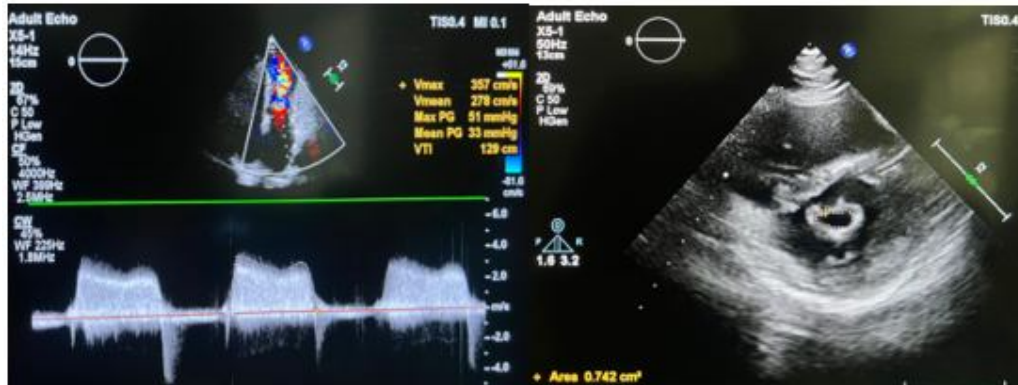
(A) Colour Doppler across MV showing turbulent jet due to MS and CW showing P/M TMG of 51/33 mm Hg suggestive of severe MS. (B) PSAX view showing Fish mouth appearance of MV in open state in diastole with MV area of 0.74 cm² by Planimetry.
